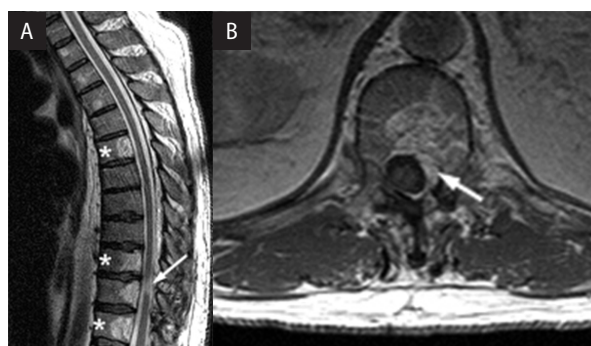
A. Sagittal view of thoracic spine revealing multiple VH on a T2 weighted MR image. White arrow shows epidural extension in the lower thoracic area; B. Epidural encroachment of VH with enhancement of the stroma (arrow) on an axial T1 contrast sequence [16]
